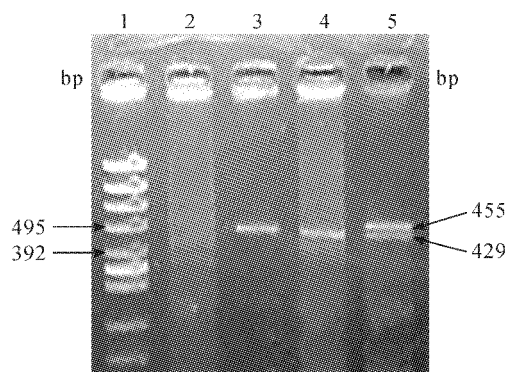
PCR reaction products. 1: marker; $\Phi \times 174$ Hinc II; lane 2: negative control; lane 3: TT genotype; lane 4: CC genotype; lane 5: CT genotype.
